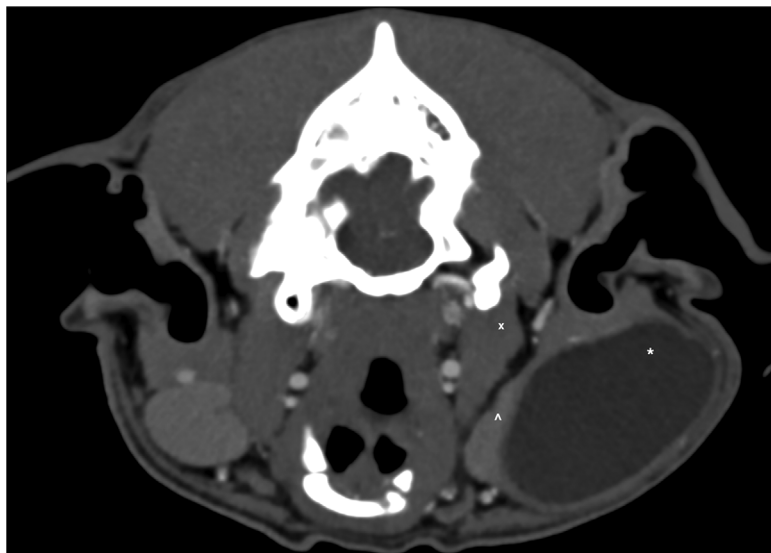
Transverse three-dimensional CT image reconstruction of the head at the level of the cystic lesion, sialocoele (*), left mandibular salivary gland (°) and the digastric muscle (x).
